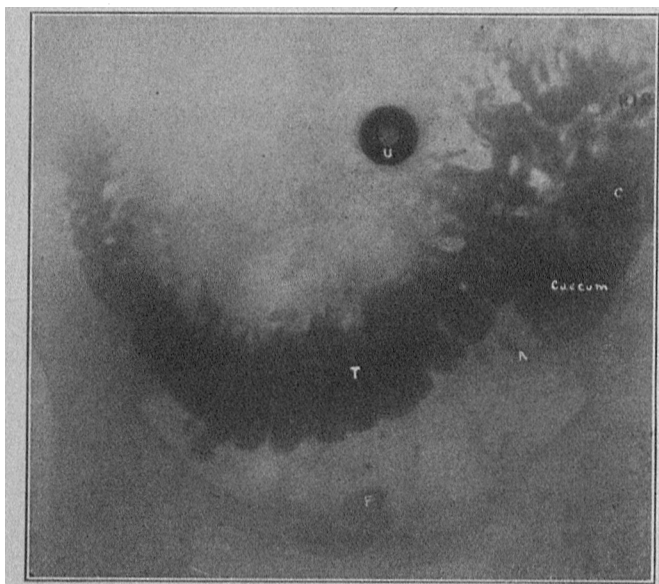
Radiograph taken twenty-six hours after the ingestion of a bismuth meal (Case 1). T, transverse colon, now become U-shaped; A, vermiform appendix, bent on itself; F, traces of bismuth in the sigmoid flexure; C, ascending colon. The lighter areas in the upper part of the colon are due to gas formation.
